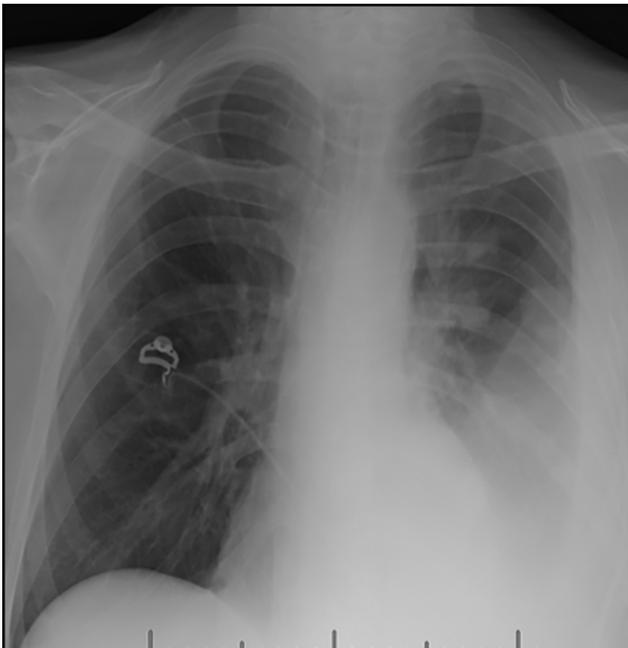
A chest radiograph revealed a new left-sided pleural effusion with adjacent consolidation.
